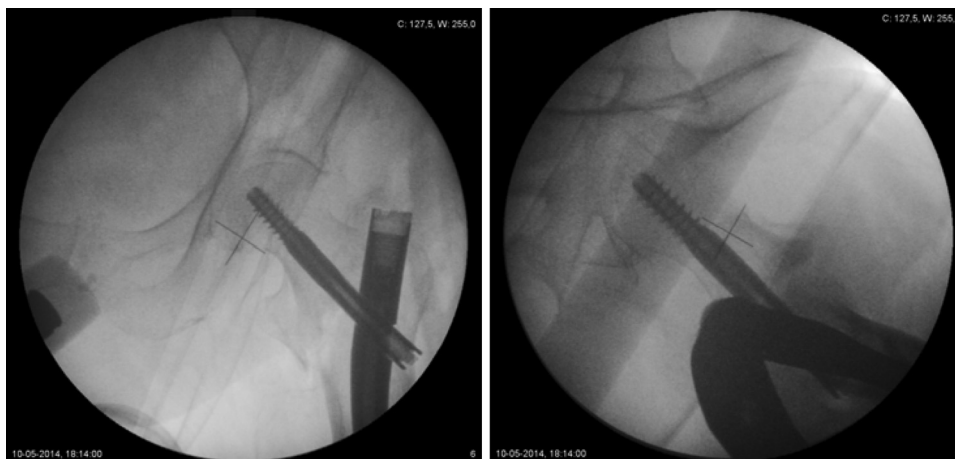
The patient underwent closed reduction and osteosynthesis with cephalomedullary screw and nail Gamma3 Stryker 130°; intraoperative radiography of the hip, anteroposterior and lateral views.
